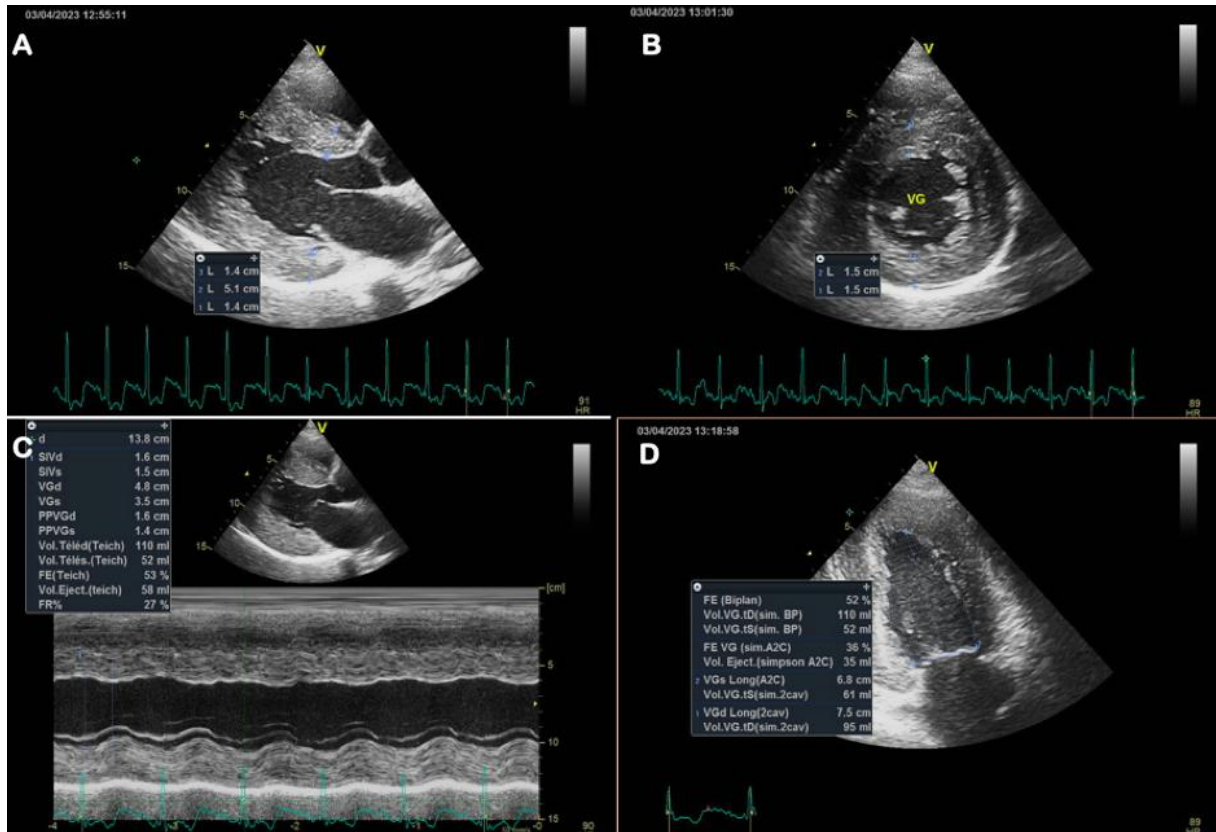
Echocardiography showed the aspect of hypertensive heart disease with normal contractility:
